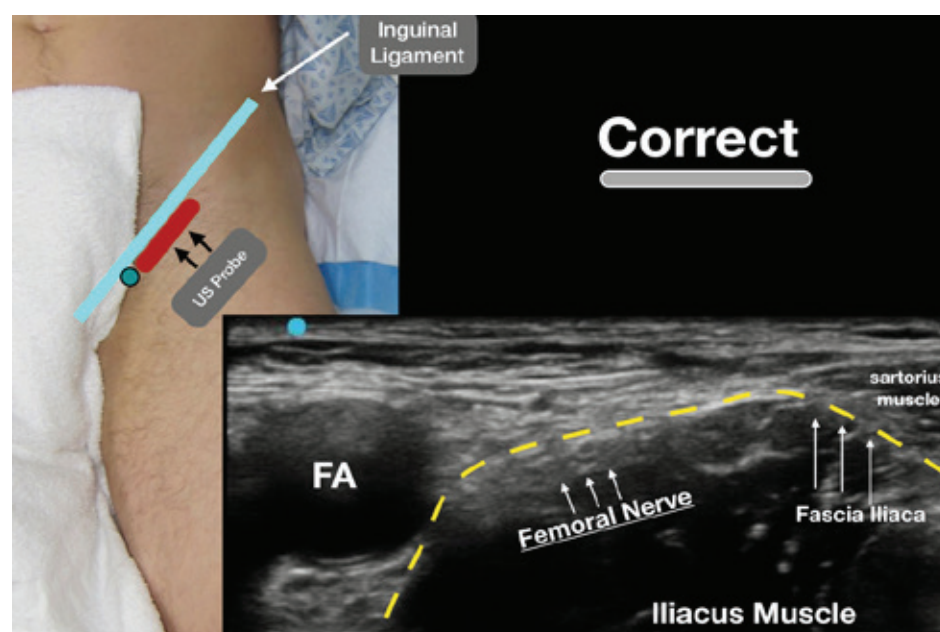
Place the ultrasound probe (with the probe marker facing to the patient's right/green circle) just under the inguinal ligament so that the relevant anatomy is clearly visualized.
